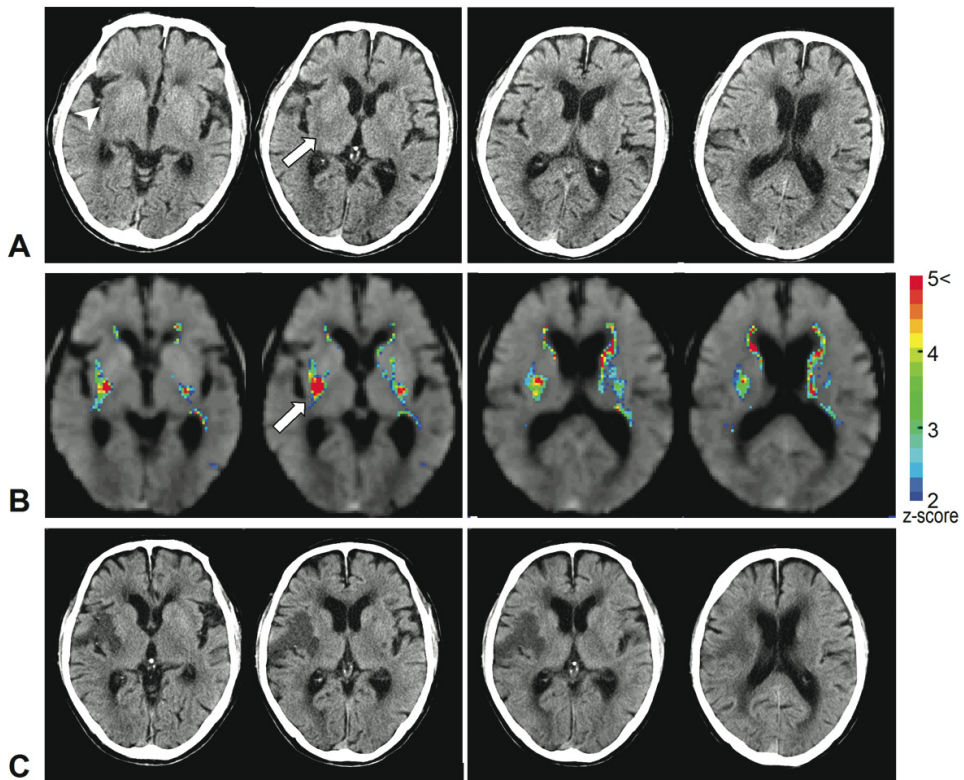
92-year-old-man with left hemiplegia at 1.3 hours after stroke onset. (A) Unenhanced CT images show that parenchymal hypoattenuation at the right lentiform nucleus (an arrow) and insula (an arrow head). (B) The z-score maps enabled four observers to avoid missing hypoattenuation at the right lentiform nucleus (a white arrow). A high-signal area is also seen within lacunar infarct in the left lentiform nucleus on the z-score maps, and moreover, a high-signal area which might be due to inaccurate normalization of enlarged cerebral ventricle appears at the left periventricular region on the z-score maps. Z scores are indicated by a color bar (*right*). (C) Follow-up CT images obtained one day after ictus demonstrate hypodense areas in the right MCA distribution.
